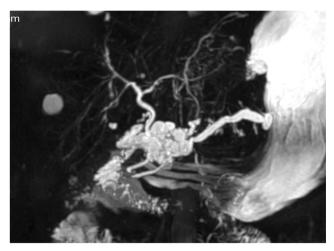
Abdominal MRI of patient 2 with heavily T2-weighted hydrographic sequences revealing microcystic lesions in the pancreatic head and hyposignal within a star-shaped structure indicative of scarring, promoting mild dilatation of the main pancreatic duct
